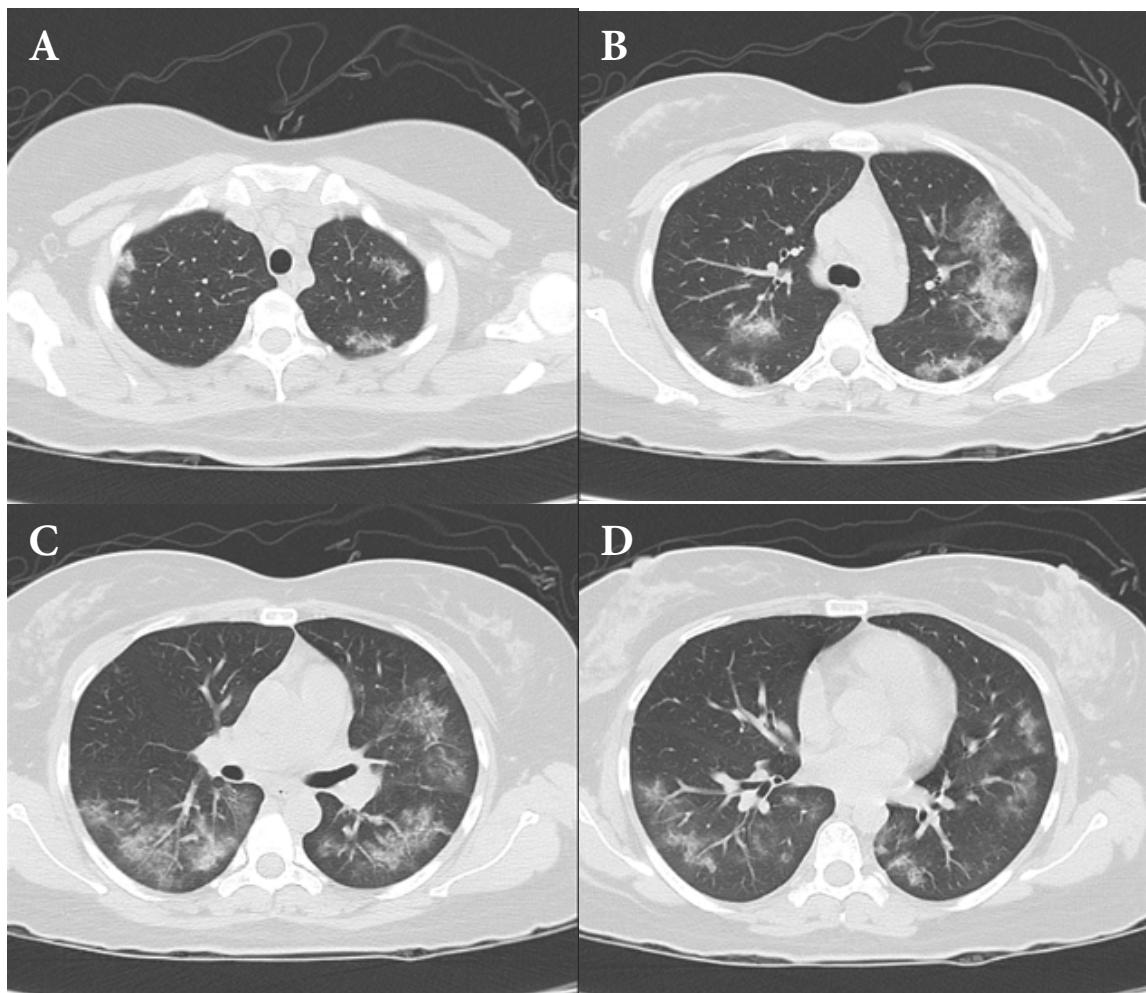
Axial non-contrast chest CT (A-D) shows crazy-paving pattern at both upper lobes and both lower lobes, involving peripheral regions with presence of subpleural sparing.
